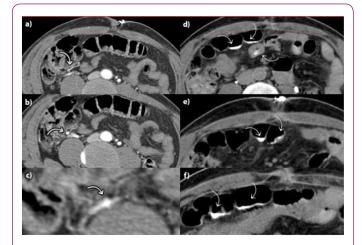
CTA performed immediately after the conventional angiography confirms the presence of short arterial segment dilatations. a) The ileocolic artery can be seen (thick arrow) immediately anterior to the ileocolic vein. b) At the level immediately below, the ileocolic artery shows a 5mm focal dilatation (thick arrow). c) Close-up of the ileocolic artery in MPR through the micro-aneurysm (thick arrow). d - f) Intra-luminal contrast medium (thin arrows) confirms active bleeding of low output, which was not identified during angiography.
